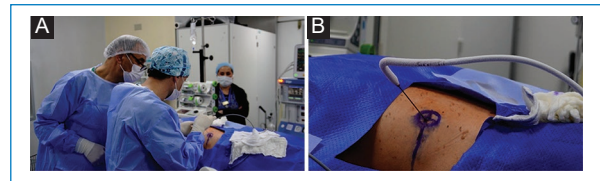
A: placement of the percutaneous cryoablation needle in a cT1a renal tumor guided by computed tomography. B: position of the percutaneous cryoablation needle in the skin during the freezing phase.
